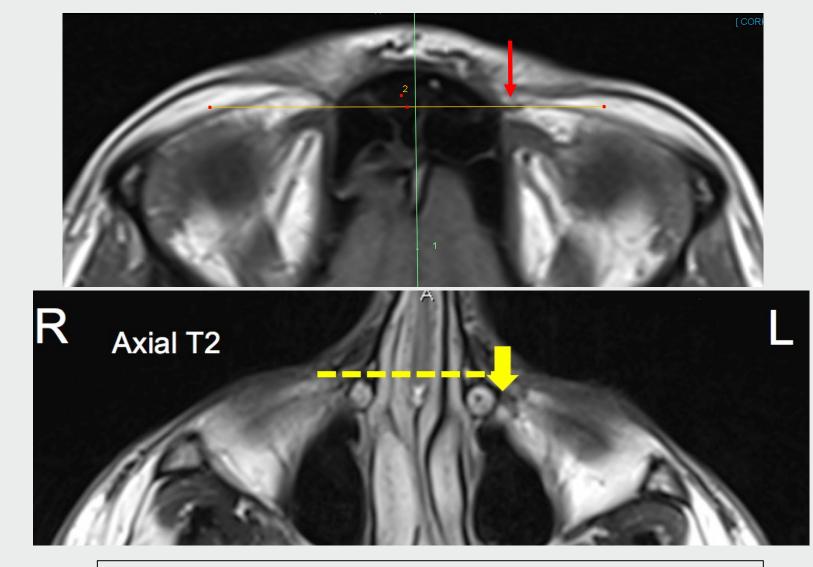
(Top) MRI shows postero-placed left trochlea (red arrow) in a patient with apparent left SO palsy. (Bottom) MRI shows postero-placed origin of left inferior oblique (yellow arrow) in a patient who presented with right inferior oblique overaction and presumed right SO palsy
